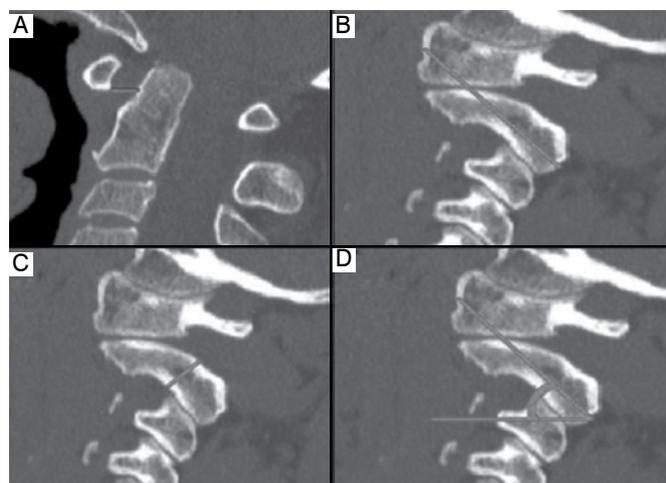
Model of obtainment of measurements in the sagittal section of the C1-C2 CT scan. (A) posterior cortex of the anterior arch of C1 and anterior odontoid cortex. (B) Length of C2 pedicle + C1 lateral mass (from the posterior cortex of the C2 pars, obliquely, towards the anterior cortex of the C1 lateral mass). (C) Thickness of C2 pedicle at its narrowest point and perpendicular to its longest measurement from the posterior superior pedicle cortex to the anterior inferior pedicle cortex. (D) Angle of attack to the horizontal for entrance of the C2 posterior cortex screw, crossing the pedicle and heading to the anterior cortex of the C1 lateral mass.*- Measurements B, C and D were made individually on the left and right sides.
